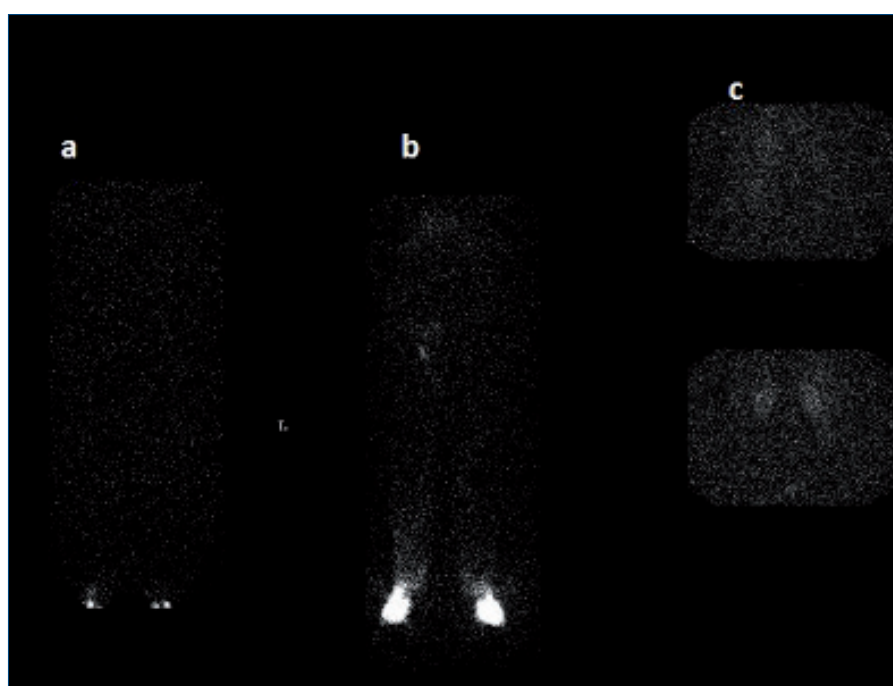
Lymphoscintigraphy: a) first image showed no sign of migration ten minutes after introducing the tracer b) three and a half hours later, a second image showed minimum uptake in the derma over the distal limbs and the right groin c) twenty-four hours later, abdominal images were obtained and no accumulation of activity was detected.
